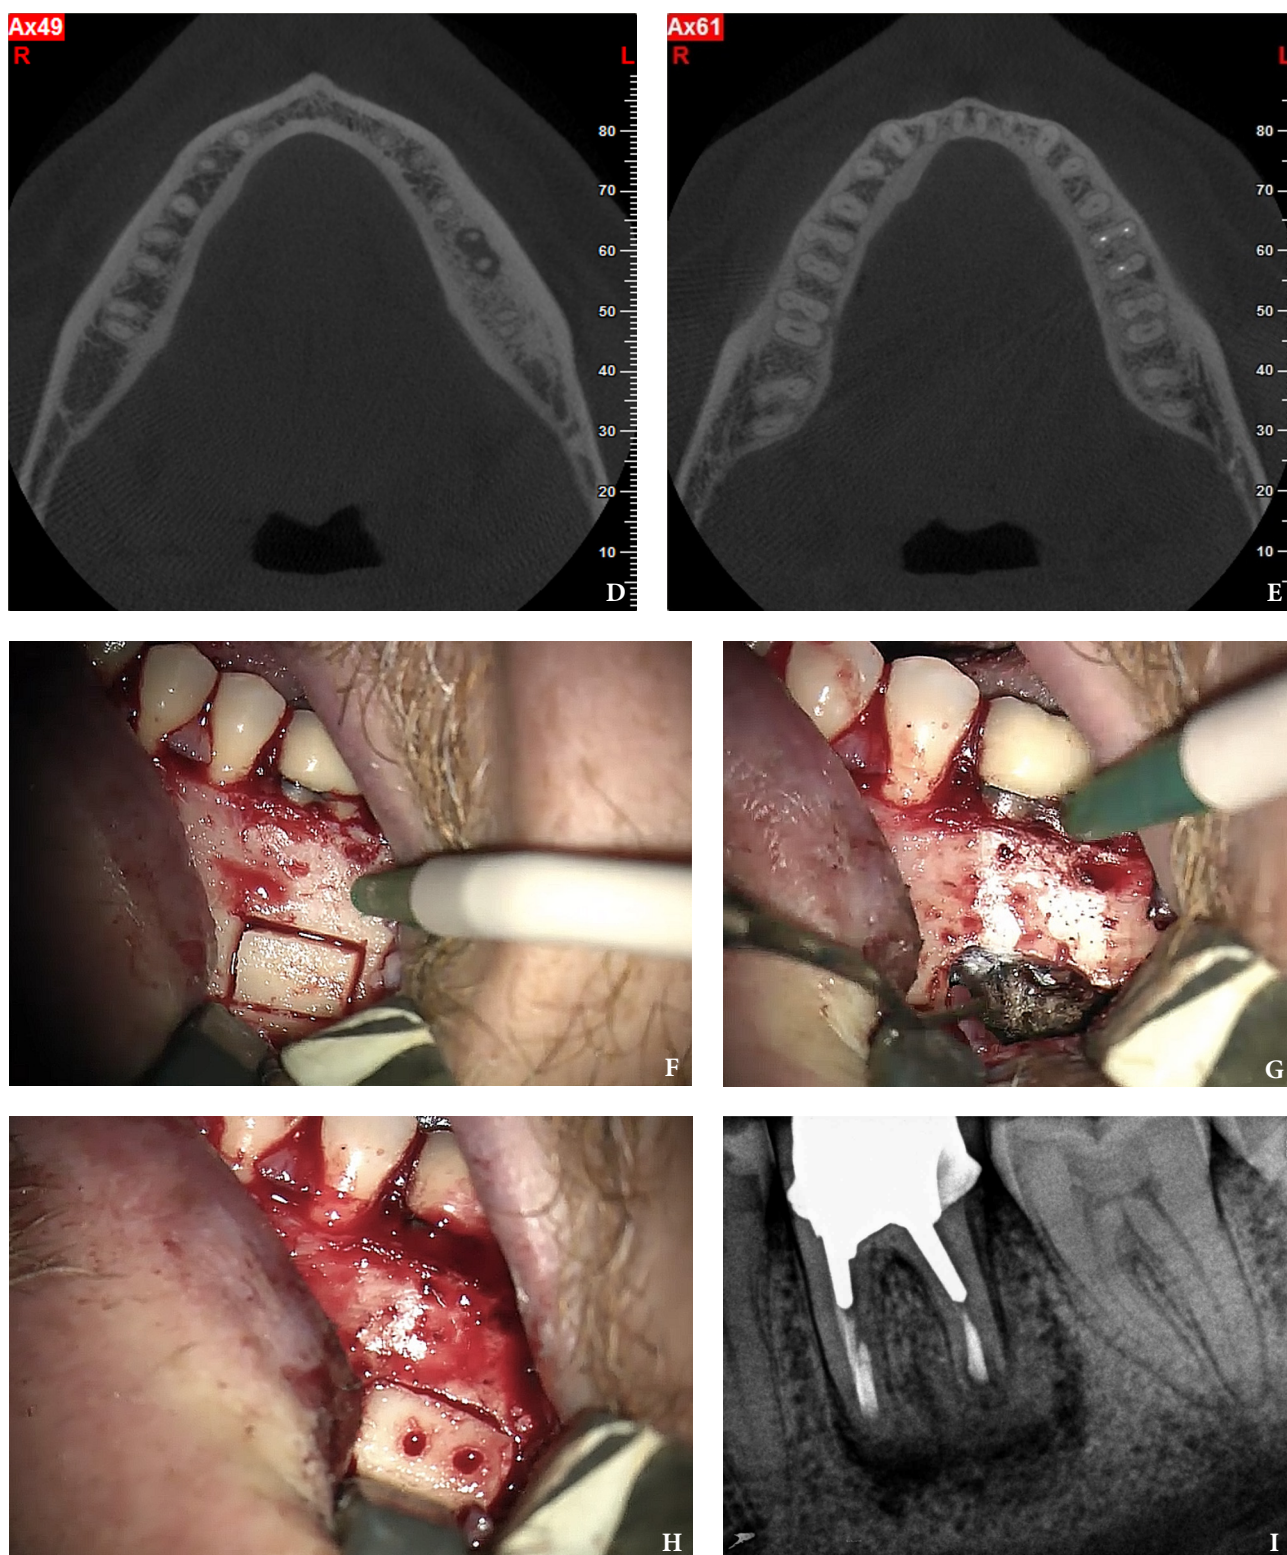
(continued). CBCT coronal (C) and axial (D, E) view demonstrating the amount of buccal bone thickness measured as well as the proximity to anatomical structures. Intraoperative clinical pictures of case 2 (tooth #36) show: the piezoelectrically created bone window (F), root end filling (G), and bone repositioned (H). Postoperative periapical radiograph (I). (FIGURE 2 continued on next page.)
